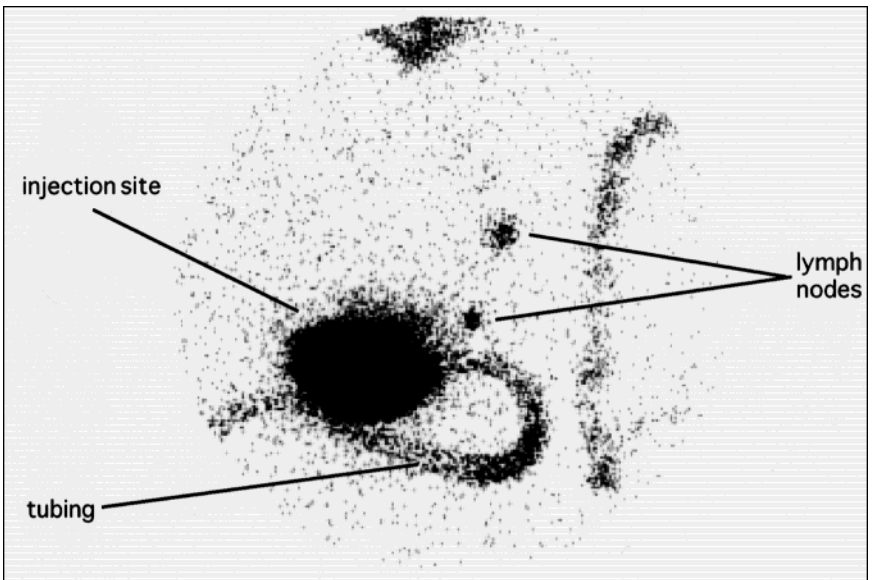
Breast lymphoscintigraphy in a patient with a nonpalpable lesion requiring ultrasound localization. Note that although a single injection site was used, there was diffuse spread of tracer over the area.
